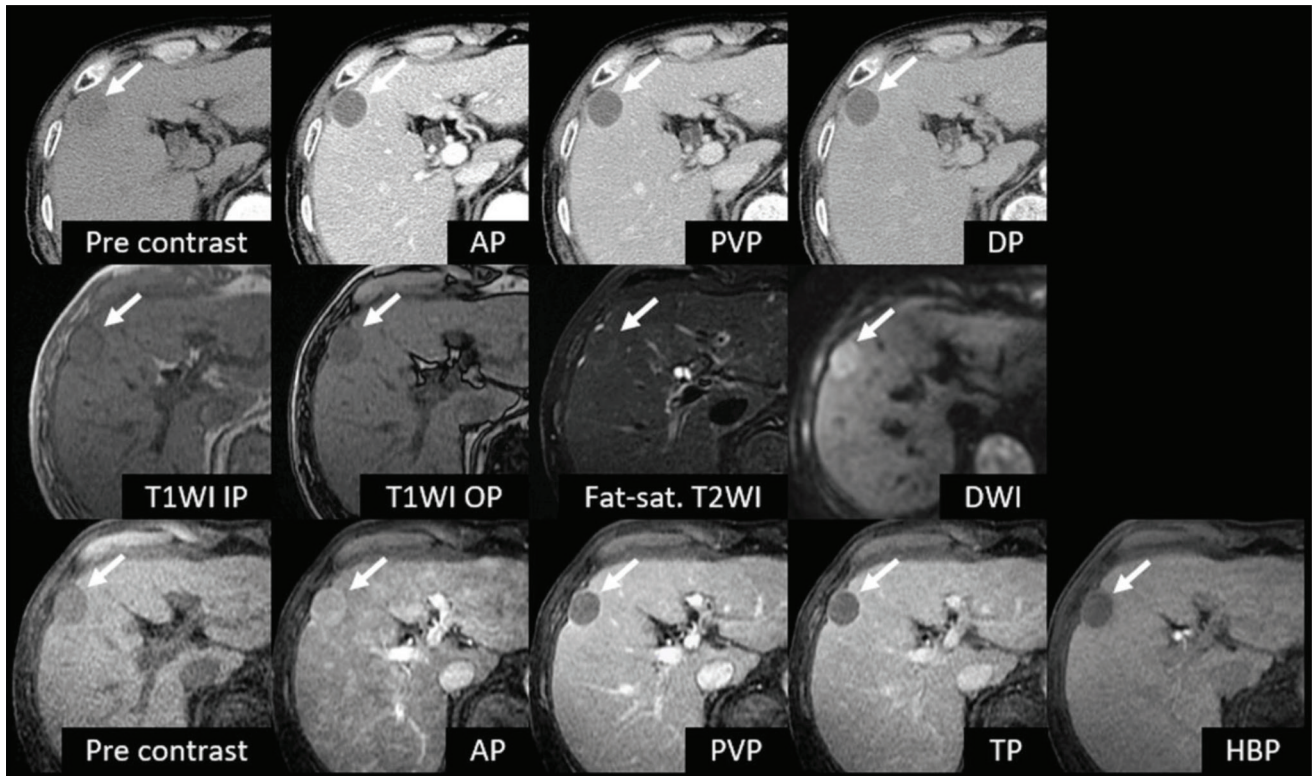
A case of hepatocellular carcinoma (HCC) misdiagnosed as “other lesion” (a category that includes benign and non-HCC malignant lesions) on computed tomography (CT) while correctly diagnosed on magnetic resonance imaging (MRI). The top row shows CT images and the middle and bottom rows show MR images. A 73-year-old man had HCC (22 mm) at S5 (arrows). This lesion showed rim arterial phase hyperenhancement (APHE) on CT. Therefore, it was misdiagnosed as “other lesion” (benign and non-HCC malignant lesions) by the decision tree and radiologist-made practical diagnosis (reader 1 scored 2 and reader 2 scored 3 for malignancy). On MRI, this lesion did not show marked hyperintensity on T₂-weighted images (T₂WI). Non-rim APHE and signal drop of opposed phase (OP) were observed. Gadoteric acid uptake on hepatobiliary phase (HBP) was not observed. Portal venous phase (PVP) and transitional phase (TP) images on MRI showed hypointensity. This lesion was correctly diagnosed as HCC by the logistic model, decision tree of MRI, and radiologist-made practical diagnosis of MRI (both readers scored 5 for both malignancy and HCC). T₁WI, T₁-weighted image; IP, in phase; Fat-sat., fat-saturated; DWI, diffusion-weighted image.
